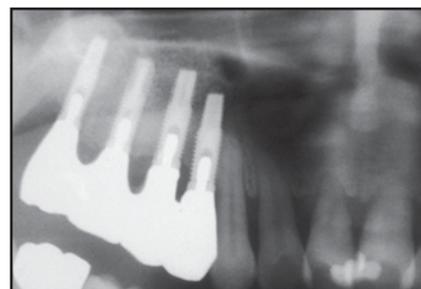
Radiograph obtained after sinus augmentation procedure.
